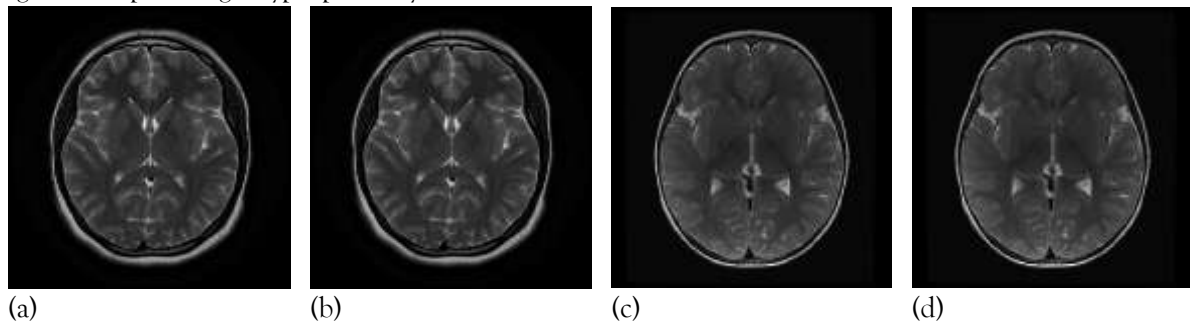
Input images type- normal MRI
